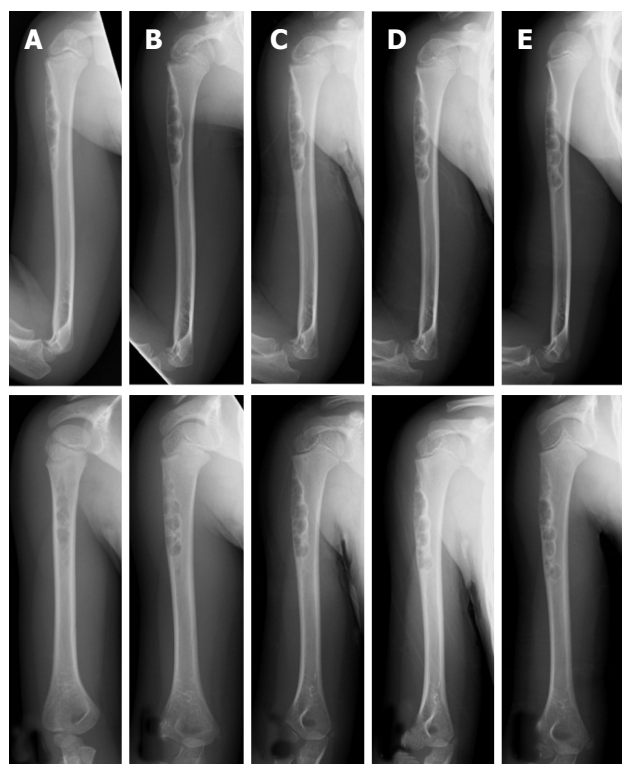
Plain radiographs of a non-ossifying fibroma in the humerus of a 4-year-old female. An osteolytic lesion is shown at the cortex in the proximal humerus (A). Radiographs taken after 7 mo (B), 1 year (C), 1 year and 7 mo (D), and 2 years and 7 mo (E) together reveal the location of the lesion became more distal with growth of the child. The size of the lesion increased as it slowly ossified (plain radiographs: Anteroposterior view, top; lateral view, bottom).
